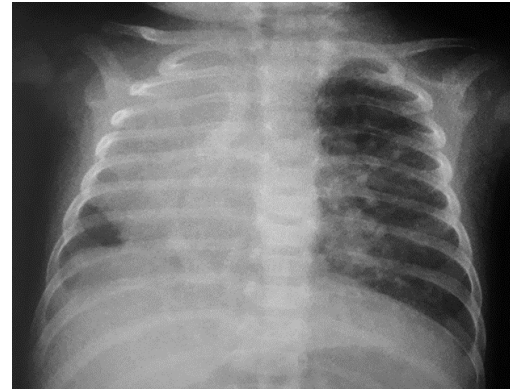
Chest X-ray; The heart is moved into the right chest; the right lung is hypoplastic.
